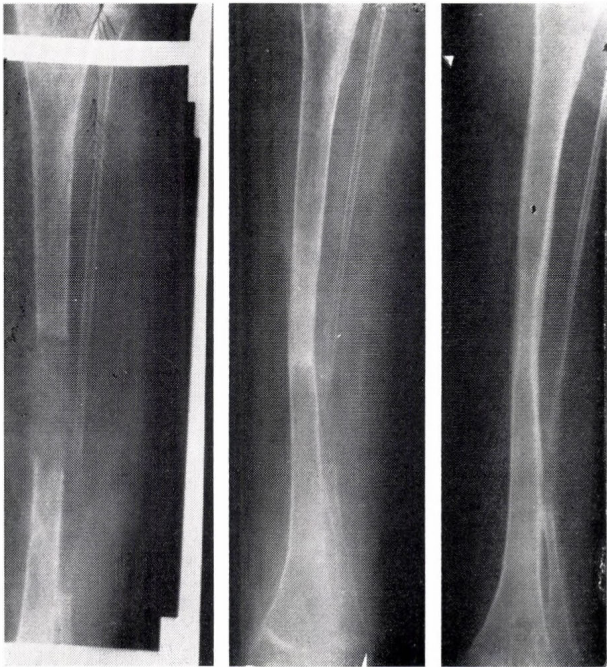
Right time of loading determined by the X-ray picture; appearance of a cortical layer
